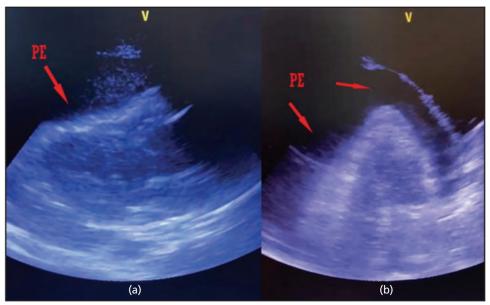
a) Subcostal view: arrow showed large pericardial effusion compressing right atrium and right ventricle. b) Apical 4 chambers view: arrows showed global pericardial effusion.
